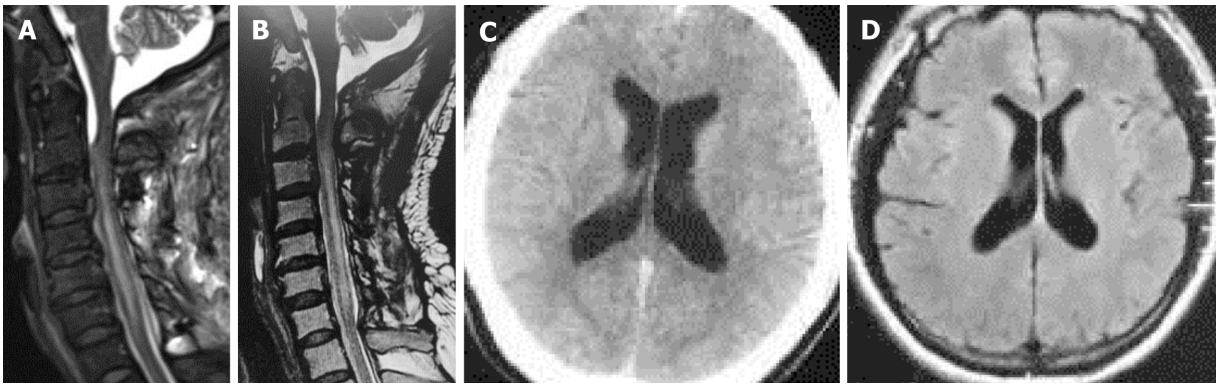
Cervical magnetic resonance imaging and brain computed tomography in follow-up period. A: Cervical magnetic resonance imaging at 2 d after dural repair showing significantly decreased pseudomeningocele and subdural fluid collection; B: Subdural fluid collection disappeared completely 15 mo after dural repair; C: Computed tomography-scan at 3 mo after dural repair demonstrated reduced hydrocephalus compared with pre-operation; D: Brain magnetic resonance at 1 year after dural repair showed that the ventricular system almost returned to normal shape.
